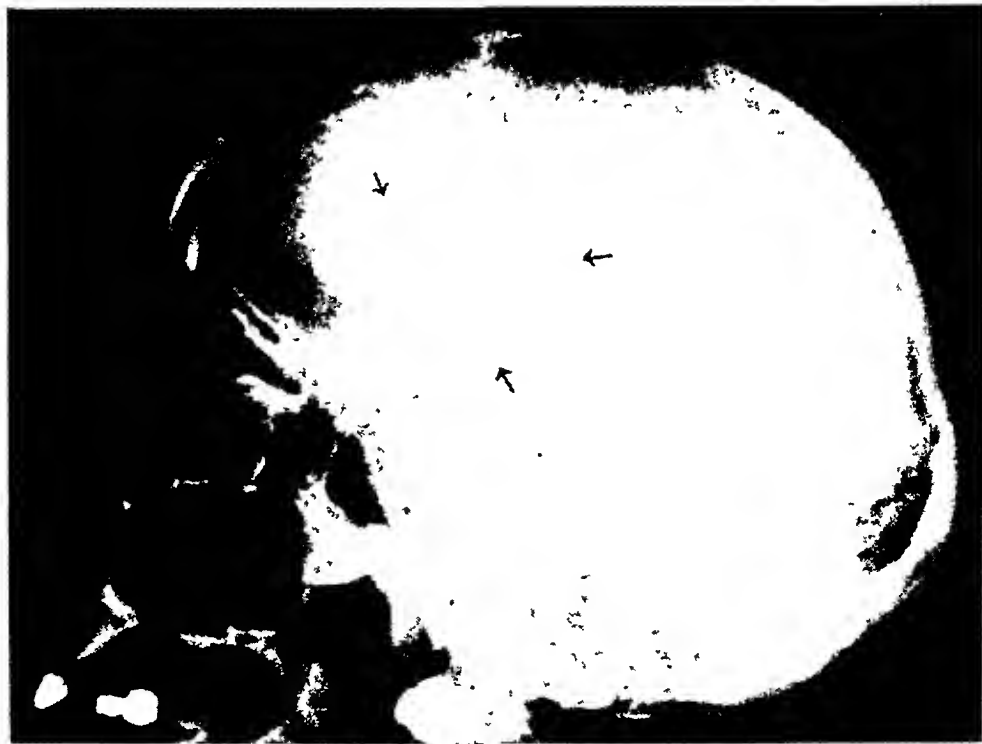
Lateral roentgenogram of the skull, showing the huge area of calcification in the frontal region.
